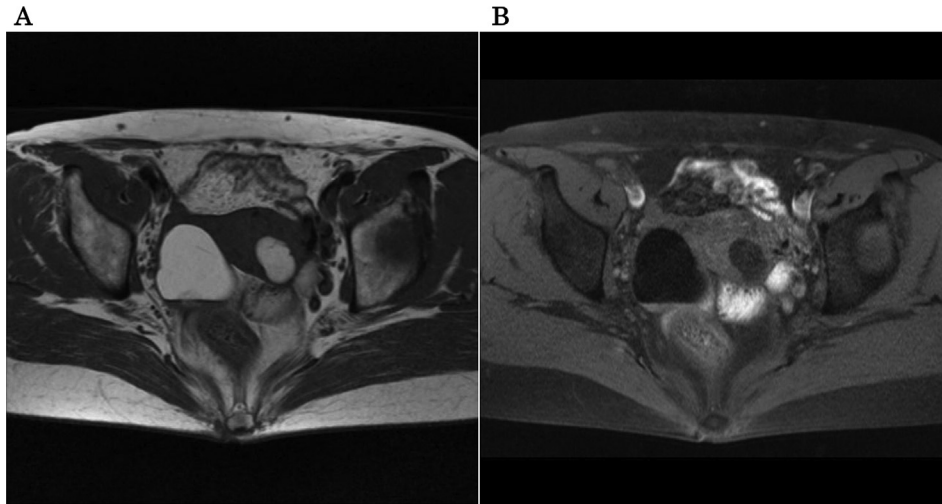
Transverse magnetic resonance imaging (MRI). (A) T1-weighted image. Both the right ovarian tumor and the posterior uterine myometrium tumor show high intensity. (B) Fat-suppression image. Both tumors have signal dropout due to fat.
